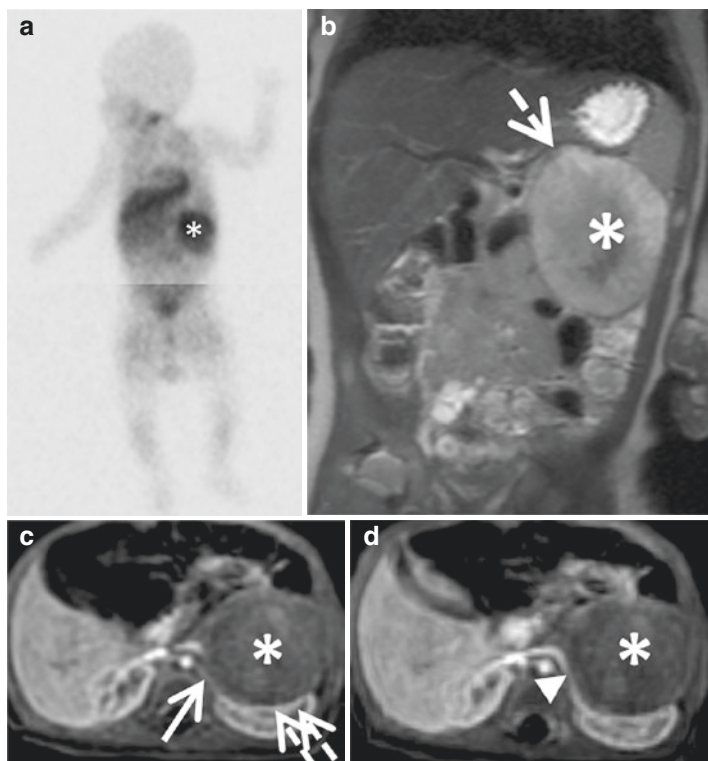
A 2-month-old girl with localized left adrenal neuroblastoma. MIBG scan (anterior view) (a) shows uptake of the primary tumor (asterisk) without distant metastasis. MR coronal T2-weighted sequence (b) shows a contact (not IDRF) with the splenic artery (dotted arrow), and contrast-enhanced transverse fat-saturated T1-weighted sequences (c, d) show displacement of the right kidney without infiltration (double dotted arrow) (not IDRF) and a contact with the renal artery (arrow) and the renal vein (arrowhead) (IDRF)
